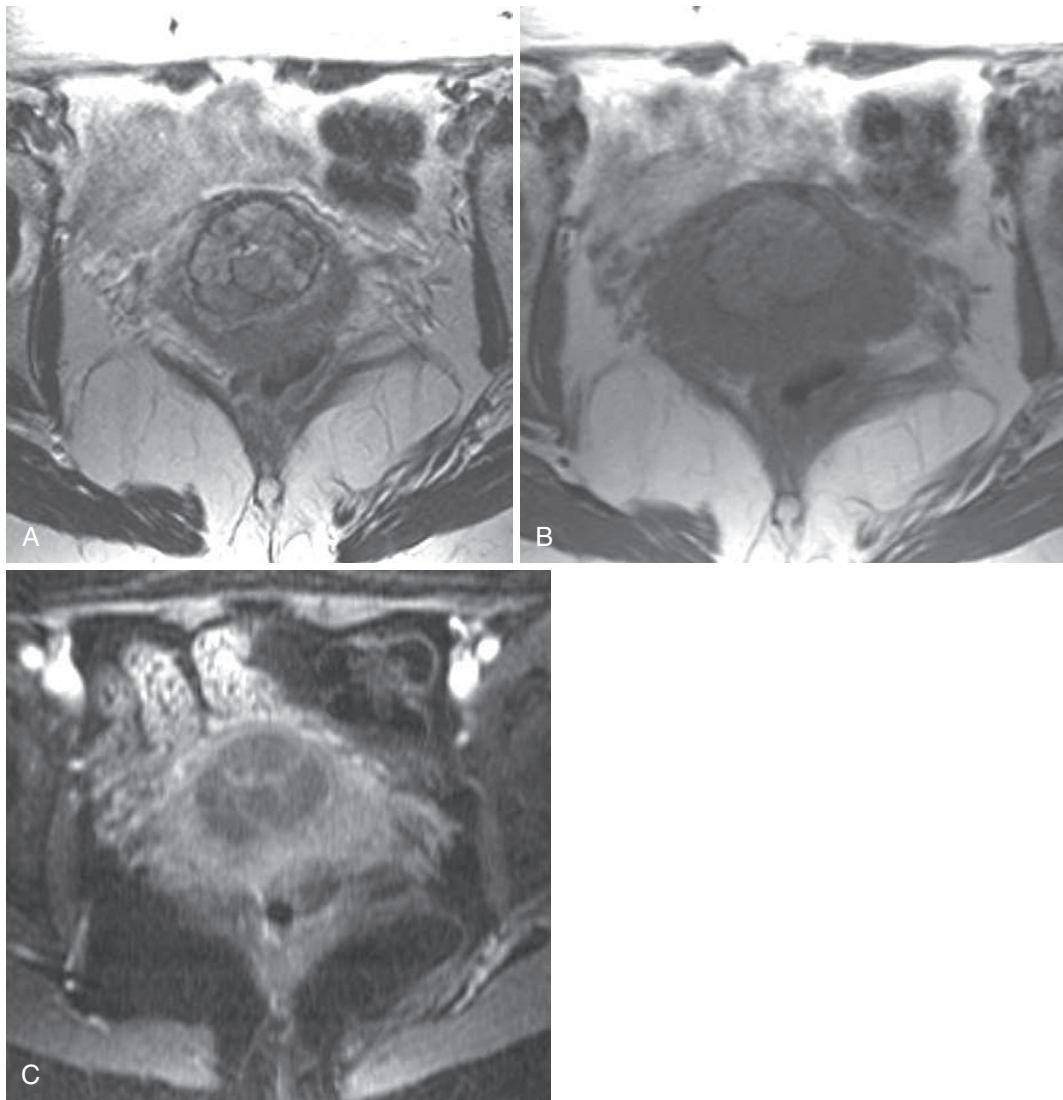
Chronic cervicitis. Axial T2-weighted (A), T1-weighted (B), and enhanced fat-suppressed T1-weighted (C) images reveal mildly hyperintense cystic cervical lesions with an absence of masslike enhancement.
